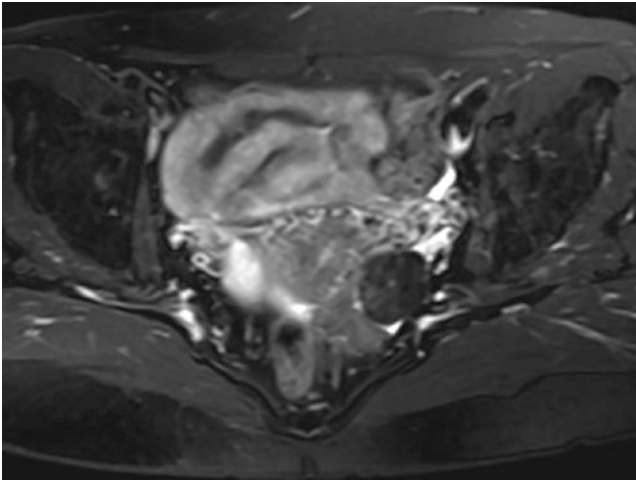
T2-weighted with fat suppression image showed the mass had significantly low signal intensity
